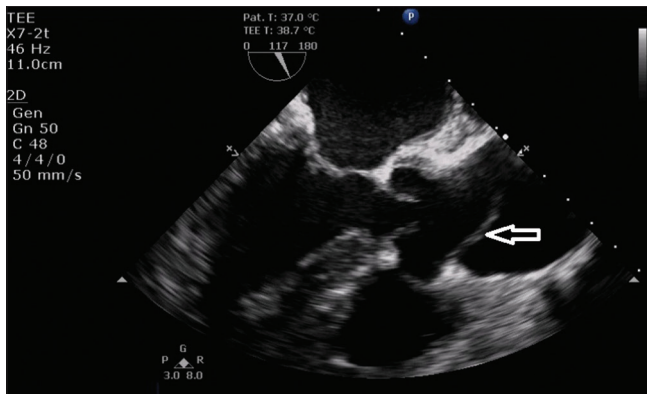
Transesophageal echocardiographic image demonstrating dissection flap (arrow) in the proximal ascending aorta (midesophageal aortic valve LAX view)
